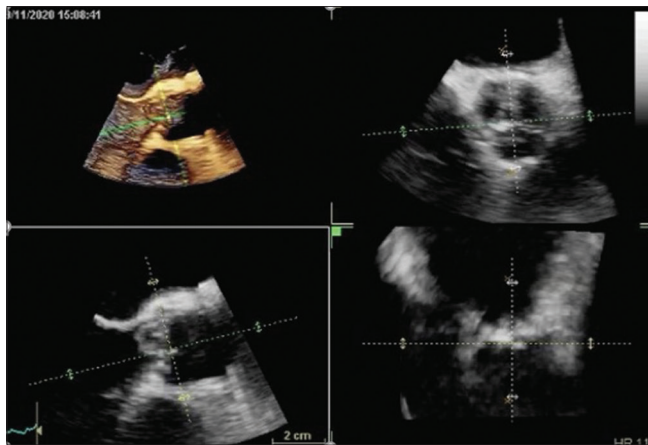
Use of three-dimensional echocardiography with multiplanar reconstruction for selecting appropriate image plane for obtaining various aortic measurements
